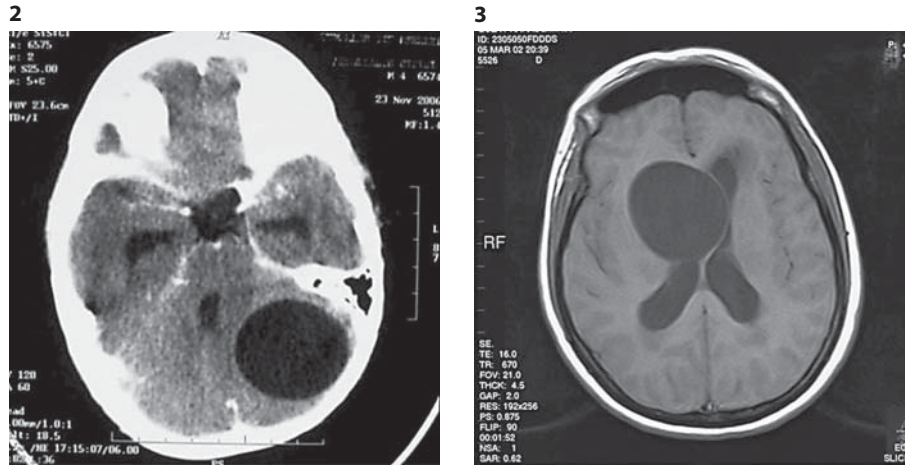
Cerebellar hydatid cyst: a round, cystic lesion without perifocal edema and enhancement on CT (note the pressure effect of the lesion to the 4th ventricle).
